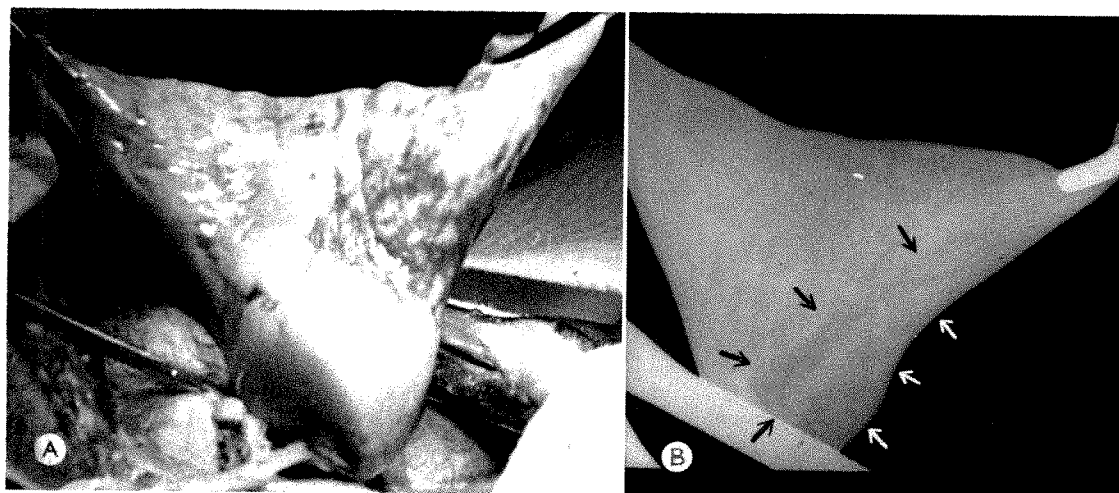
Aeration of only a single segment is demonstrated. The photograph (*A*) and roentgenogram (*B*) were taken after ten minutes of cycled ventilation at 20 cm. of water pressure through a single patent segmental bronchus.
